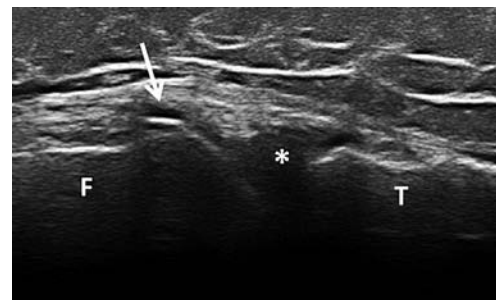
Ultrasound of the knee. Longitudinal scan of the medial aspect of the joint showing the presence of an osteophyte (↑). Normal internal meniscus (*) is also visualized. F: femur; T: tibia
